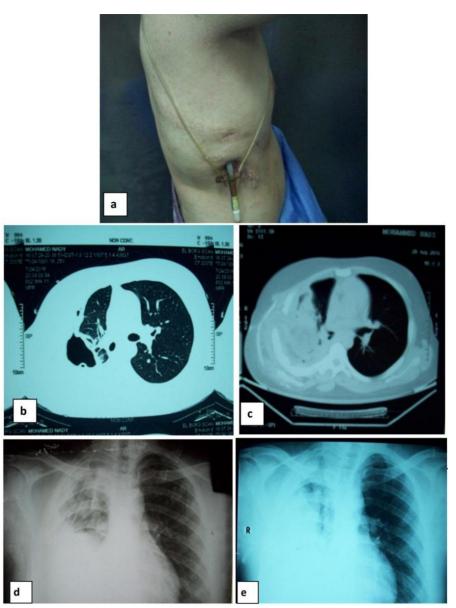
Post lobectomy patient with empyema &bronchopleural fistula treated with serratus ant. muscle flap: (a) Preoperative, (b) CT chest (axial view) showing empyema cavity (c) Intrathoracic muscle obliterating dead space and fistula, (d) Preoperative chest radiograph, (e) Postoperative showing a shadow at the right apex representing the transposed serratus muscle partially filling the cavity.
